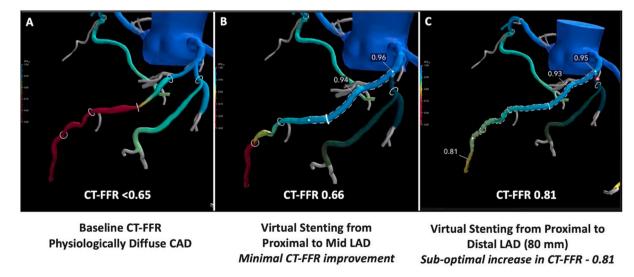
This is a case example highlighting the value of phenotyping the physiological pattern of coronary artery disease using CT-FFR and the utility CT-FFR virtual stenting planner. 67 year old male with exertional angina. A) Baseline CT-FFR model demonstrates highly positive CT-FFR < 0.65 with diffuse physiological disease along the course of the LAD. B) Virtual stenting from the proximal to mid-LAD results in a minimal improvement to CT-FFR C) Despite extensive virtual stenting of 80 mm from the proximal to distal LAD, the maximal improvement in CT-FFR was only 0.81, which represents a sub-optimal-result-.
